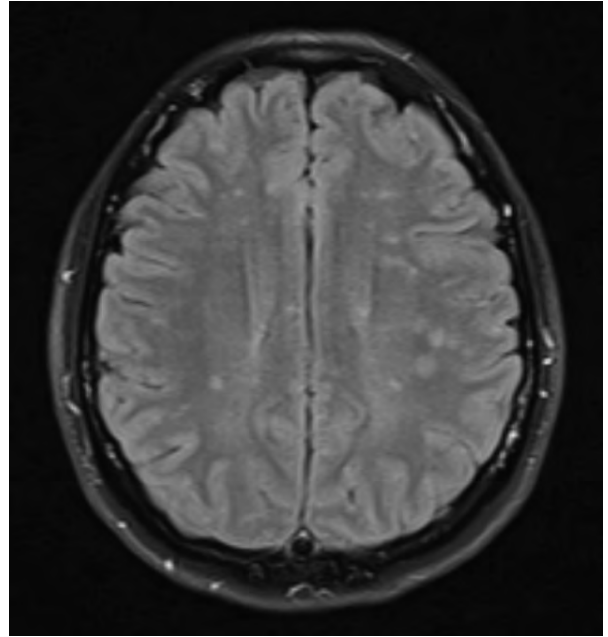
T2-weighted MRI: multifocal lesions in white matter
